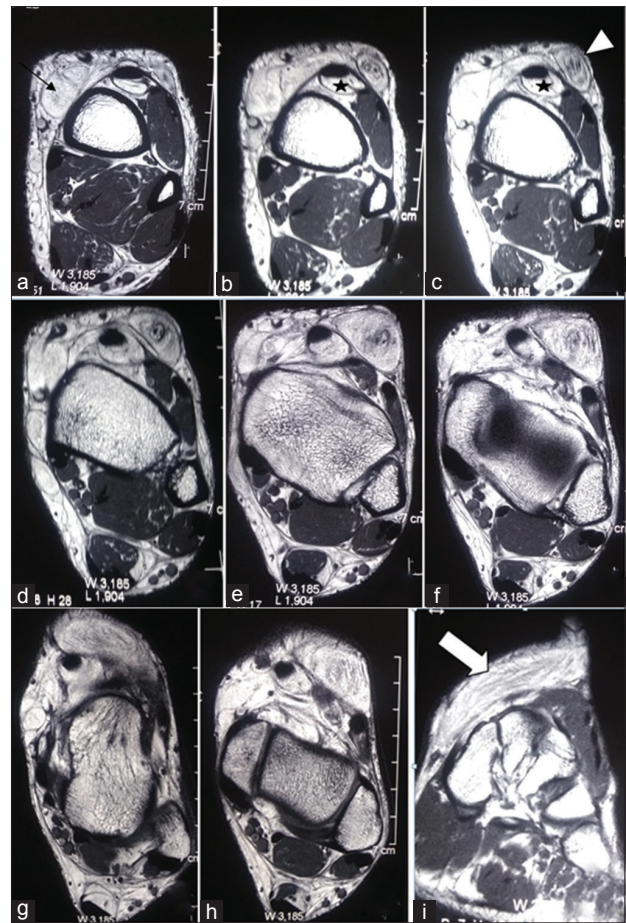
(a-i): Axial (a-h) and coronal (i) T2-weighted magnetic resonance images of the left ankle joint showing hyperintense signal inside the tibialis anterior tendon sheath (star ★).
